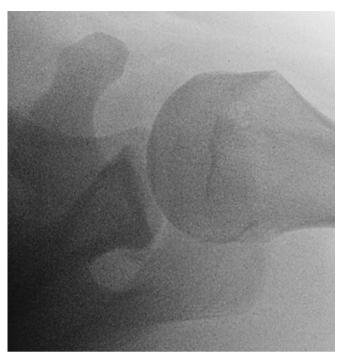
Axillary radiograph of the coracoid.
